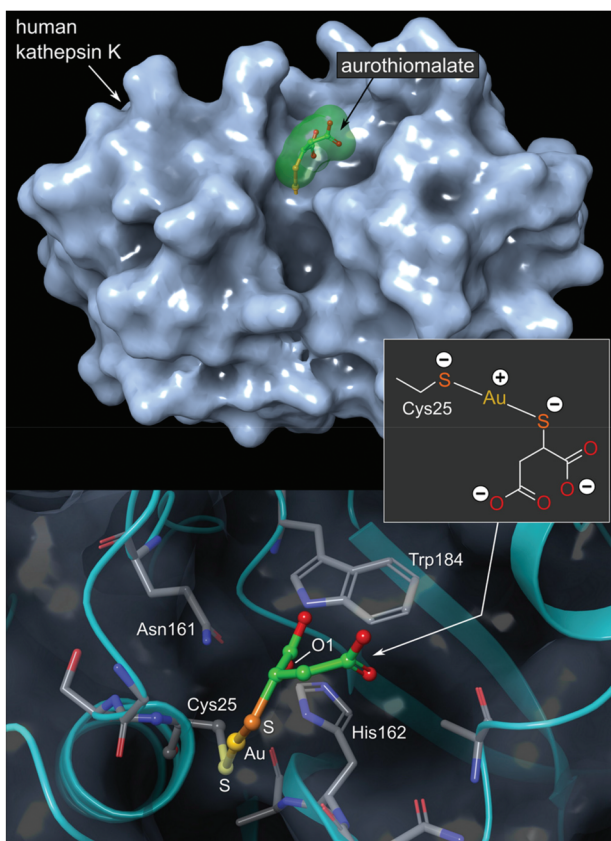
Top: View of the X-ray structure (PDB 2ATO) of human cathepsin K (a cysteine protease) covalently bound to myochrysin (aurothiomalate). The linear Au(i) thiolate targets Cys25 within the enzyme's active site cleft. Bottom: close-up view of the coordination of the Au(i) ion to the thiolate ligand of Cys25. The S–Au–S bond angle measures 173.1°; the Au–S distances are equivalent at 2.5 Å. The O1 atom of thiomalate is an acceptor for three NH...O hydrogen bonds with Gln19, His162, Trp184 (not shown).
